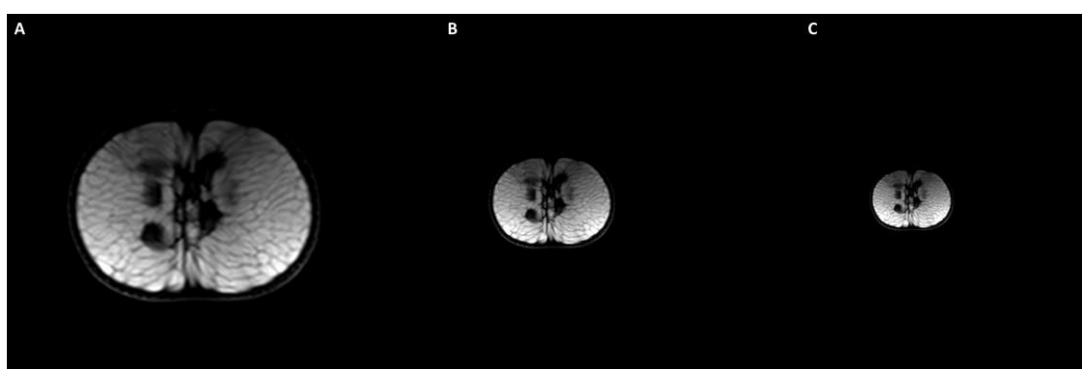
MRI Image of Tangerine fruit acquired under Field of View (FOV) of 100 (A), 200 (B) and 300 (C) millimeters, respectively.
